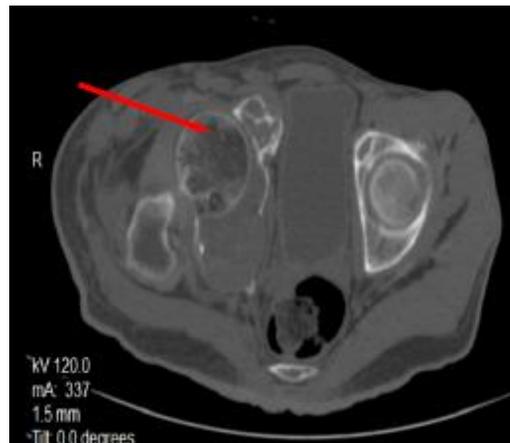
CT scan of the pelvis identifying a bone tumor in the right wing of the iliac bone, measuring approximately 9 cm x 9 cm.
